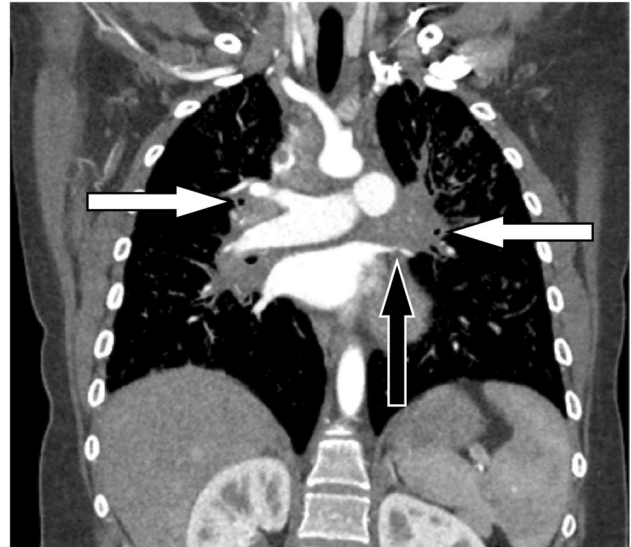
17-year-old girl with fibrosing mediastinitis due to histoplasmosis infection. Coronal reformatted chest CT image with IV contrast material shows confluent, infiltrative soft tissue involving the mediastinum and both hila that encases and narrows bilateral bronchi (white arrows) and the left upper pulmonary vein (black arrow)
